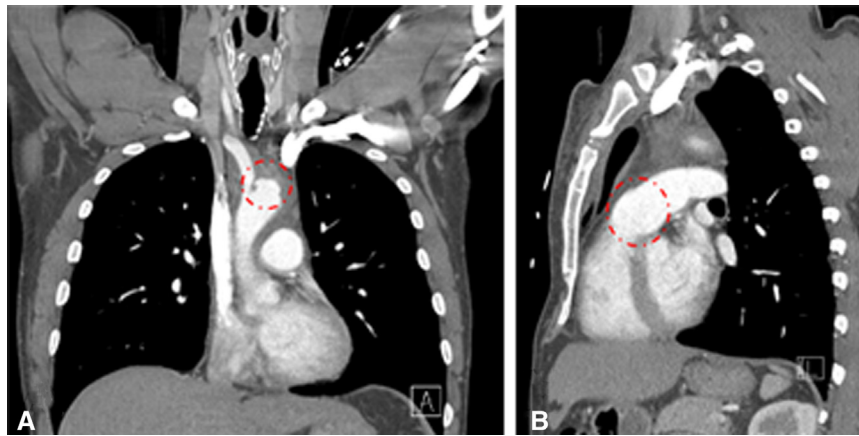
Initial computed tomography angiography demonstrating the ascending aortic pseudoaneurysm (*dashed circle*) in the coronal (A) and sagittal (B) views.
